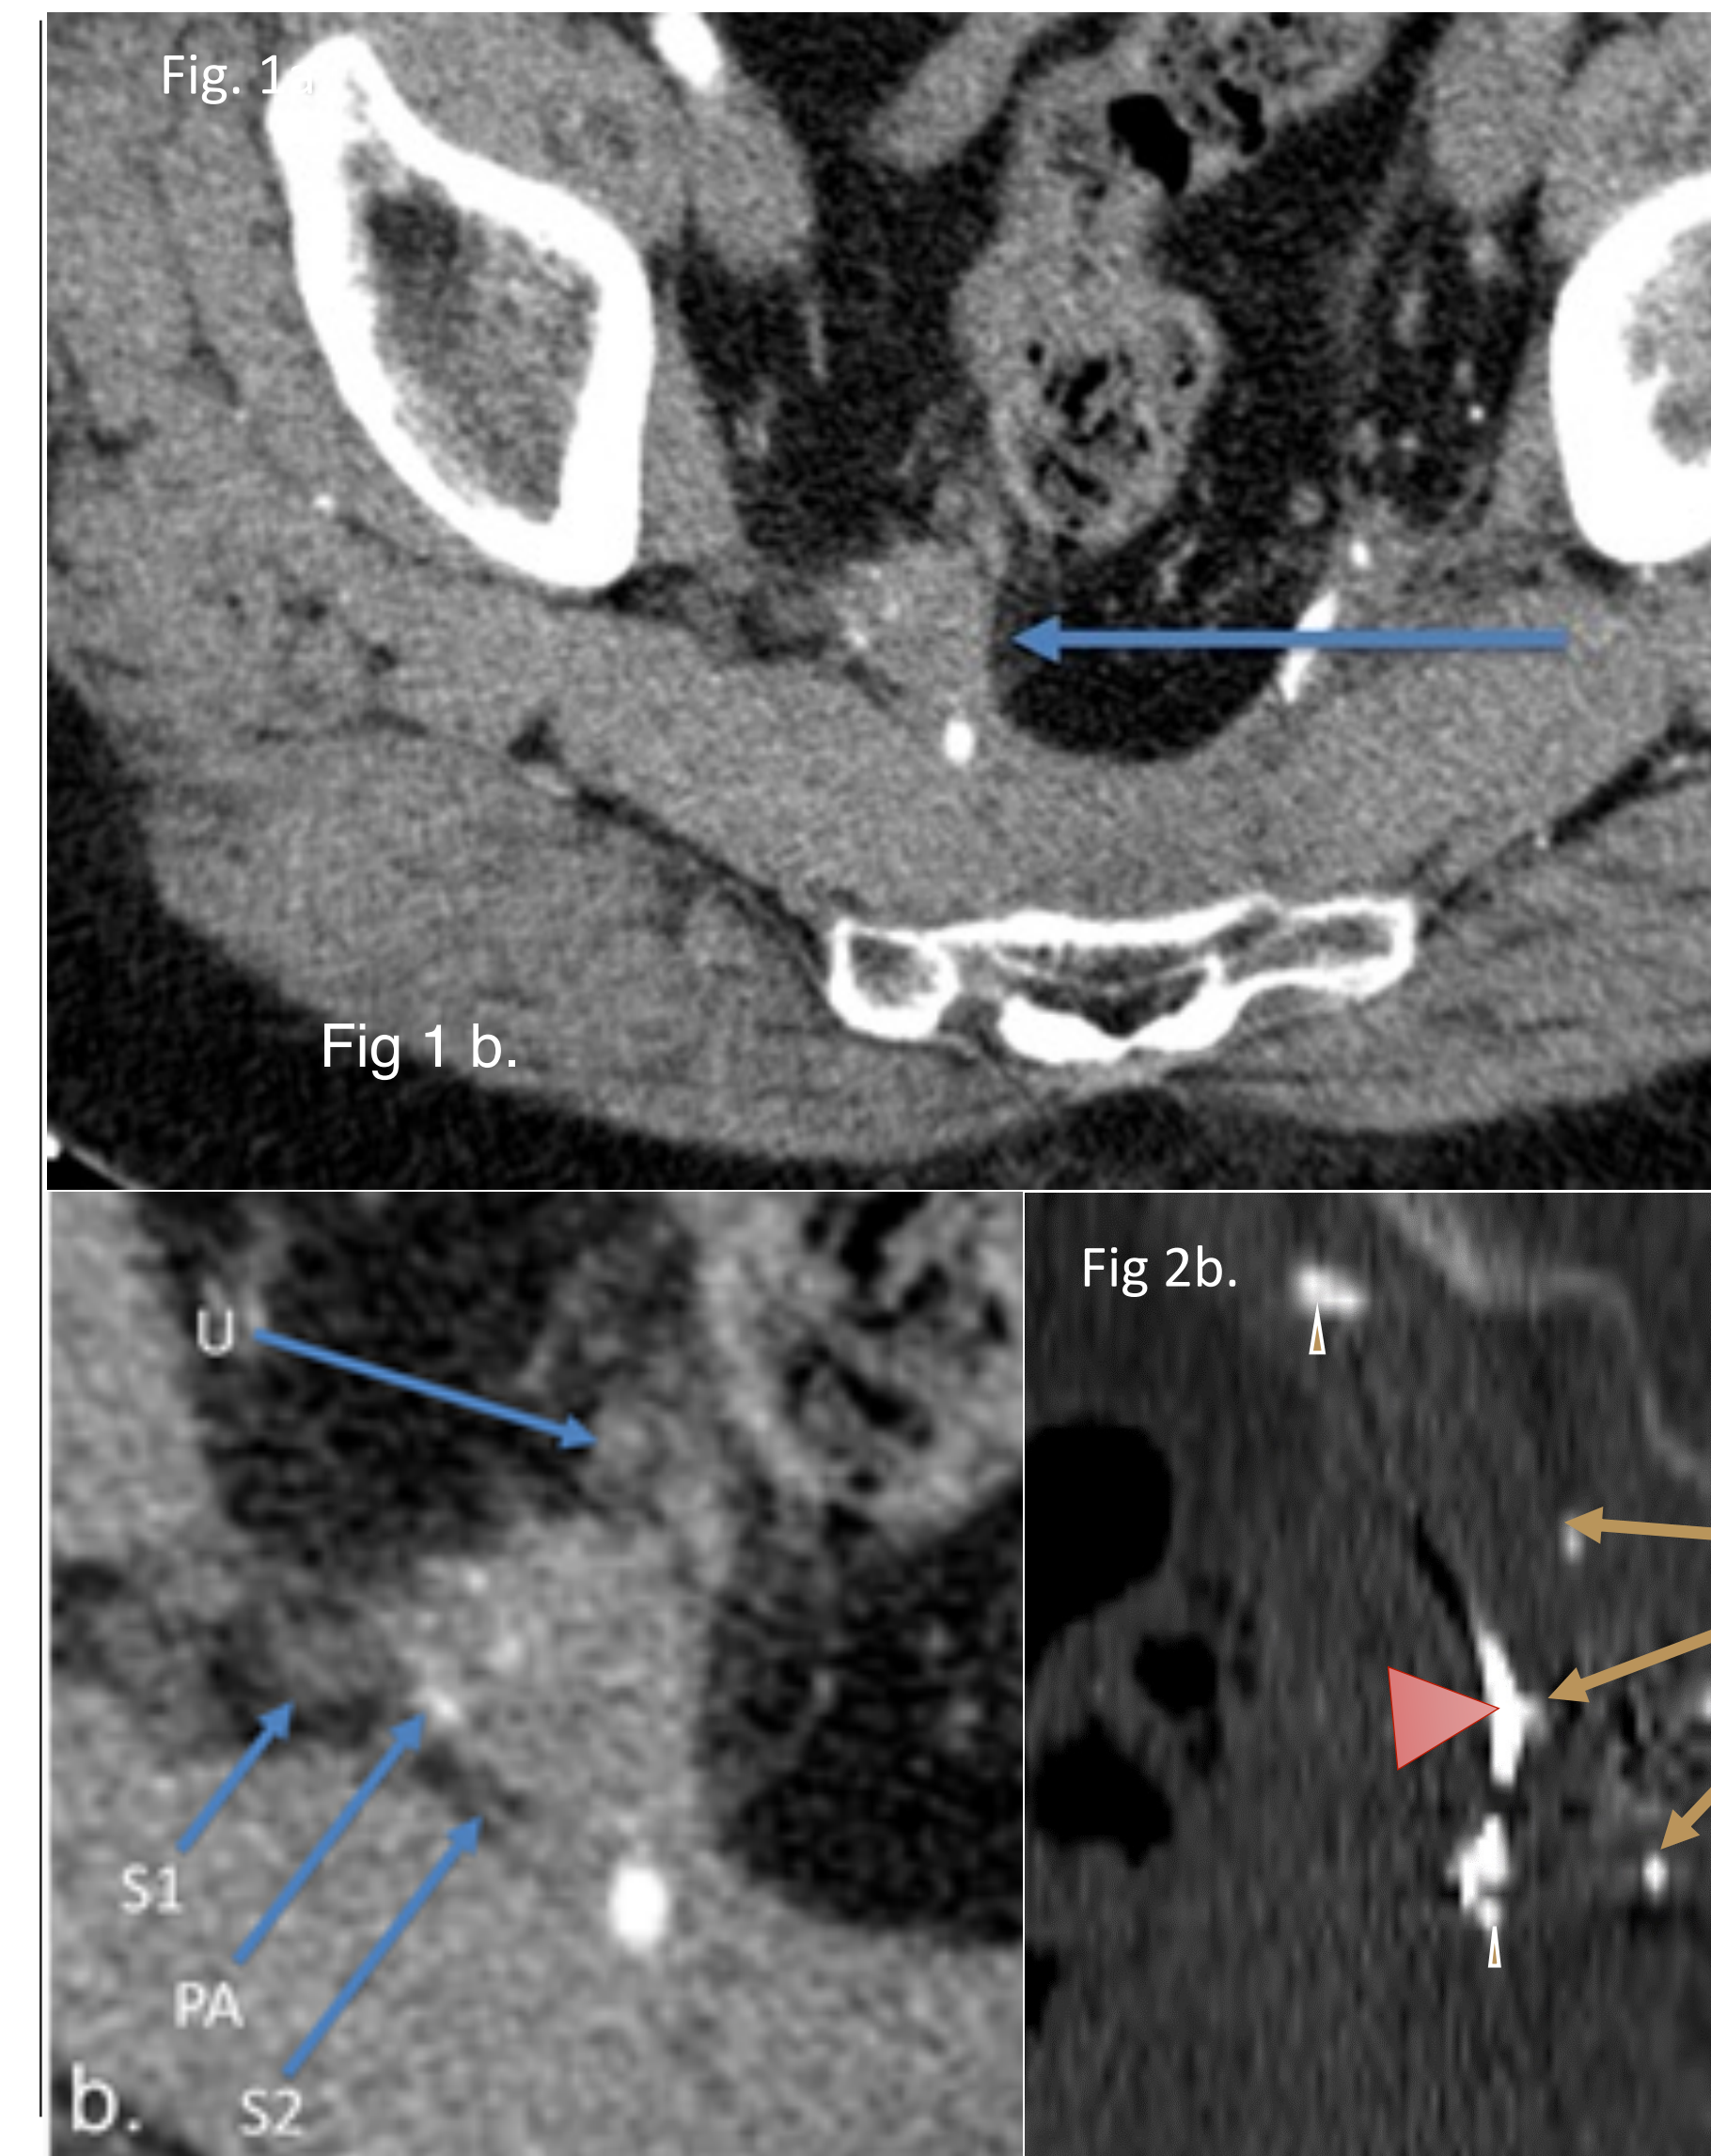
Patient 1 CT Pelvis. Right internal iliac lymph node metastasis. 1b. Zoomed in view shows adjacent structures: pudendal artery (PA), ureter (U), S1 nerve root (S1), S2 nerve root (S2). Note sigmoid colon was resected prior to IRE.
